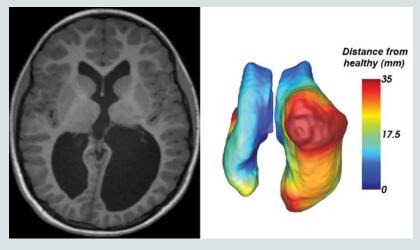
Structural MRI of patient with cerebral palsy displaying severely enlarged lateral ventricles. The extent of enlargement relative to healthy ventricles is displayed on the right.
